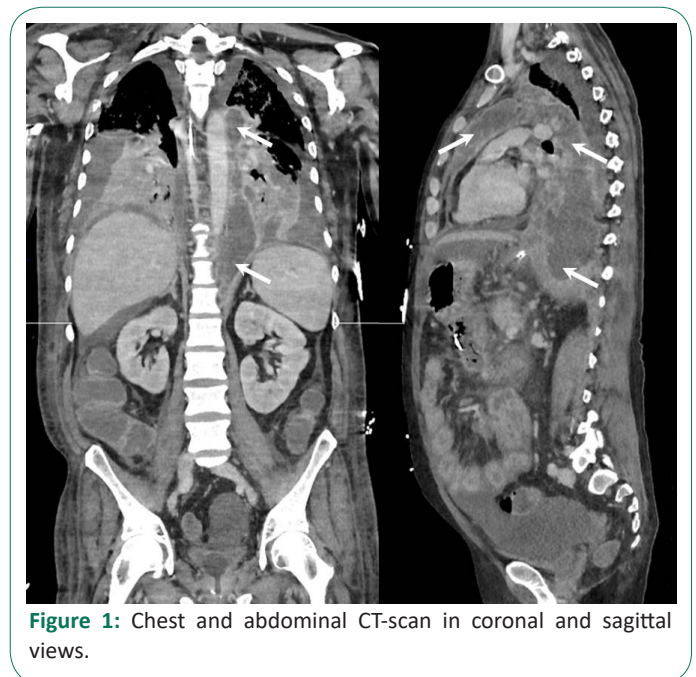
Chest and abdominal CT-scan in coronal and sagittal views.
